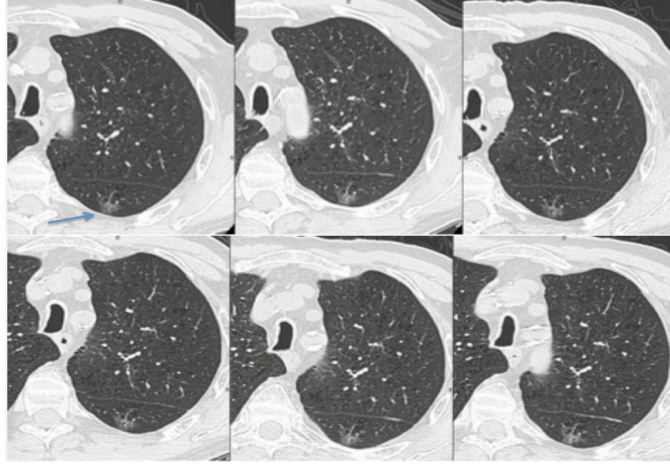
Patient 2: Six serial CT images over a span of 932 days for a stable GGO (arrow), clinically considered benign due to lack of change in size or density.
